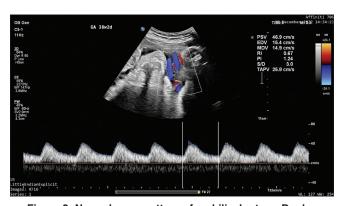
Normal wave pattern of umbilical artery: Duplex ultrasound image of a 38-week 2- day fetal umbilical cord sampled at free loop showing continuous unidirectional and forward flow throughout the cardiac cycle
